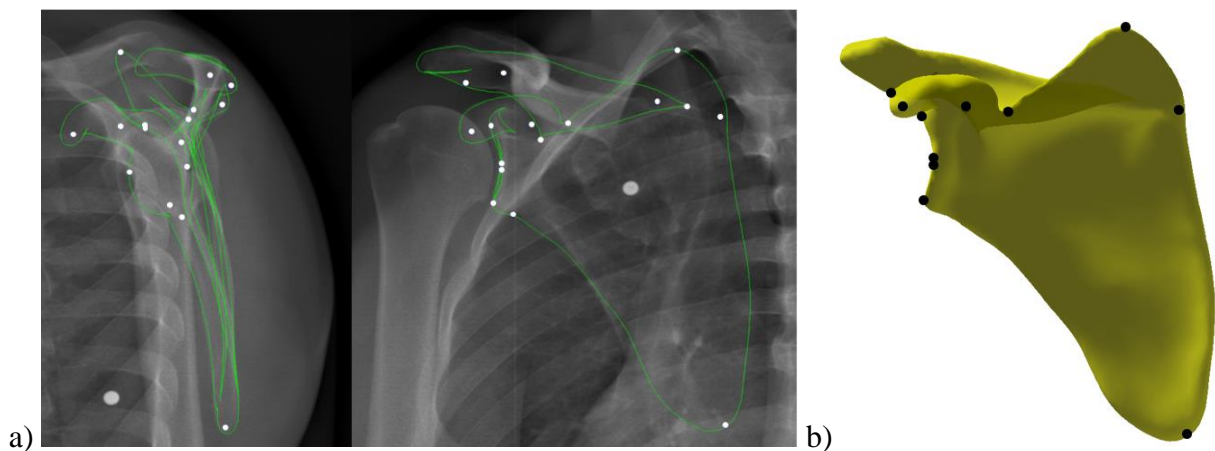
MLS deformation handle in the first phase of manual refinement a) : on the biplanar radiograph b) on a 3D model
